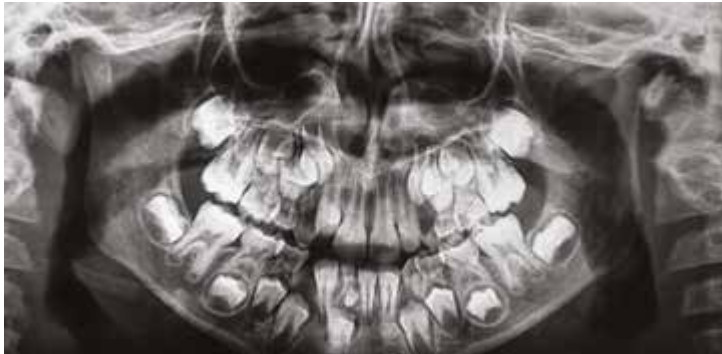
Panoramic x-ray (taken by a previous dentist 2 years before our first visit) shows the presence of an odontoma causing the retention of tooth 41.
